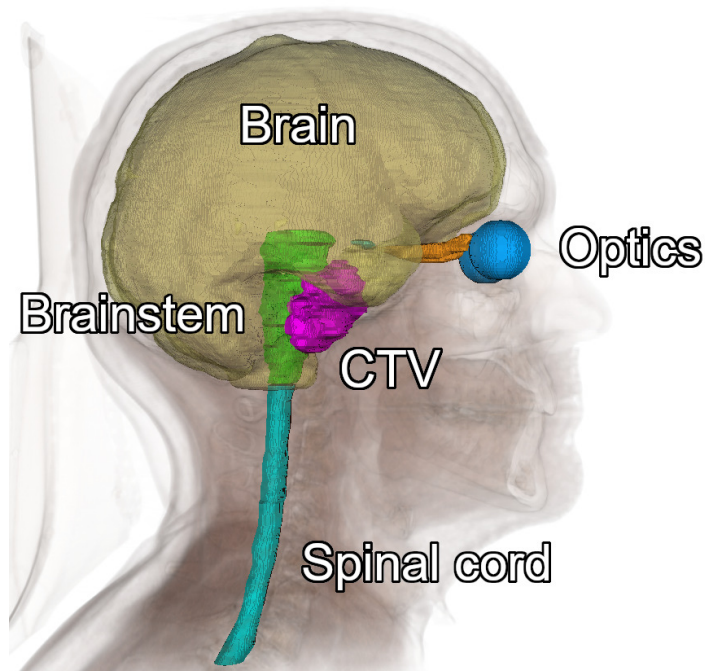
A treatment planning CT scan and delineated structures required for treatment planning. Structures are generally defined on discrete slices of the patient CT, but this figure depicts closed surfaces instead for clarity. CTV refers to the clinical target volume.
